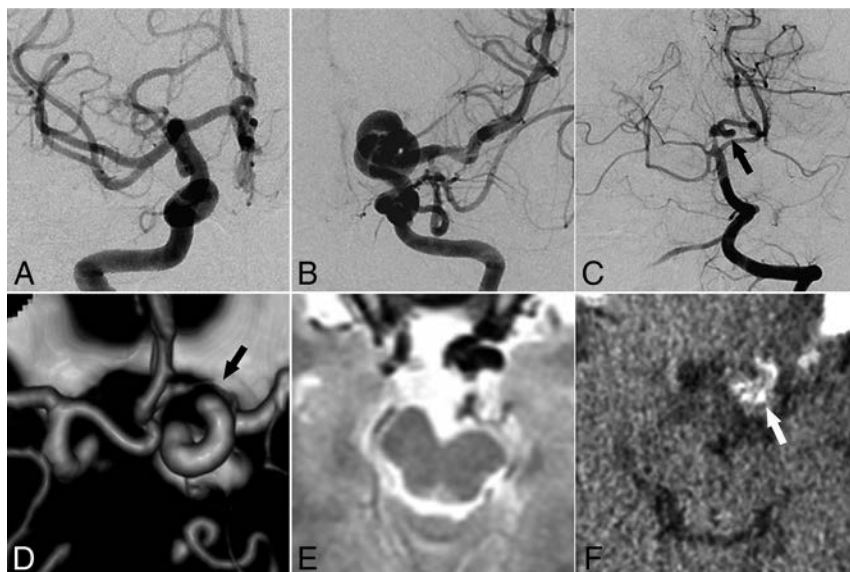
Representative images of ICDE in a patient without PHACE syndrome (patient 6, a 28-year-old woman). A and B, Bilateral ICA angiography shows a tangled arterial mass of the left distal ICA and no observable left A1 segment. C, Left vertebral artery angiography shows a dolichoectasia of the left P1 and P2 segments (arrow). D, CT angiography shows hypoplasia of the left A1 segment (arrow). E, T2-weighted image of the brain shows hypoplasia of the left midbrain. F, CT image of vessel wall calcification in the left distal ICA (arrow).
